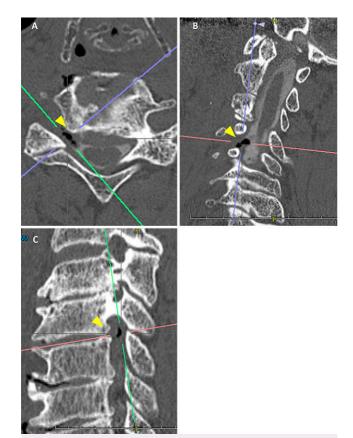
Preoperative cervical multiplanar computed tomography (CT). The yellow arrowheads indicate gas collection at the right C4–5 foramen. A: Axial CT at C4–5. B: Anterior oblique CT. C: Posterior oblique CT.
